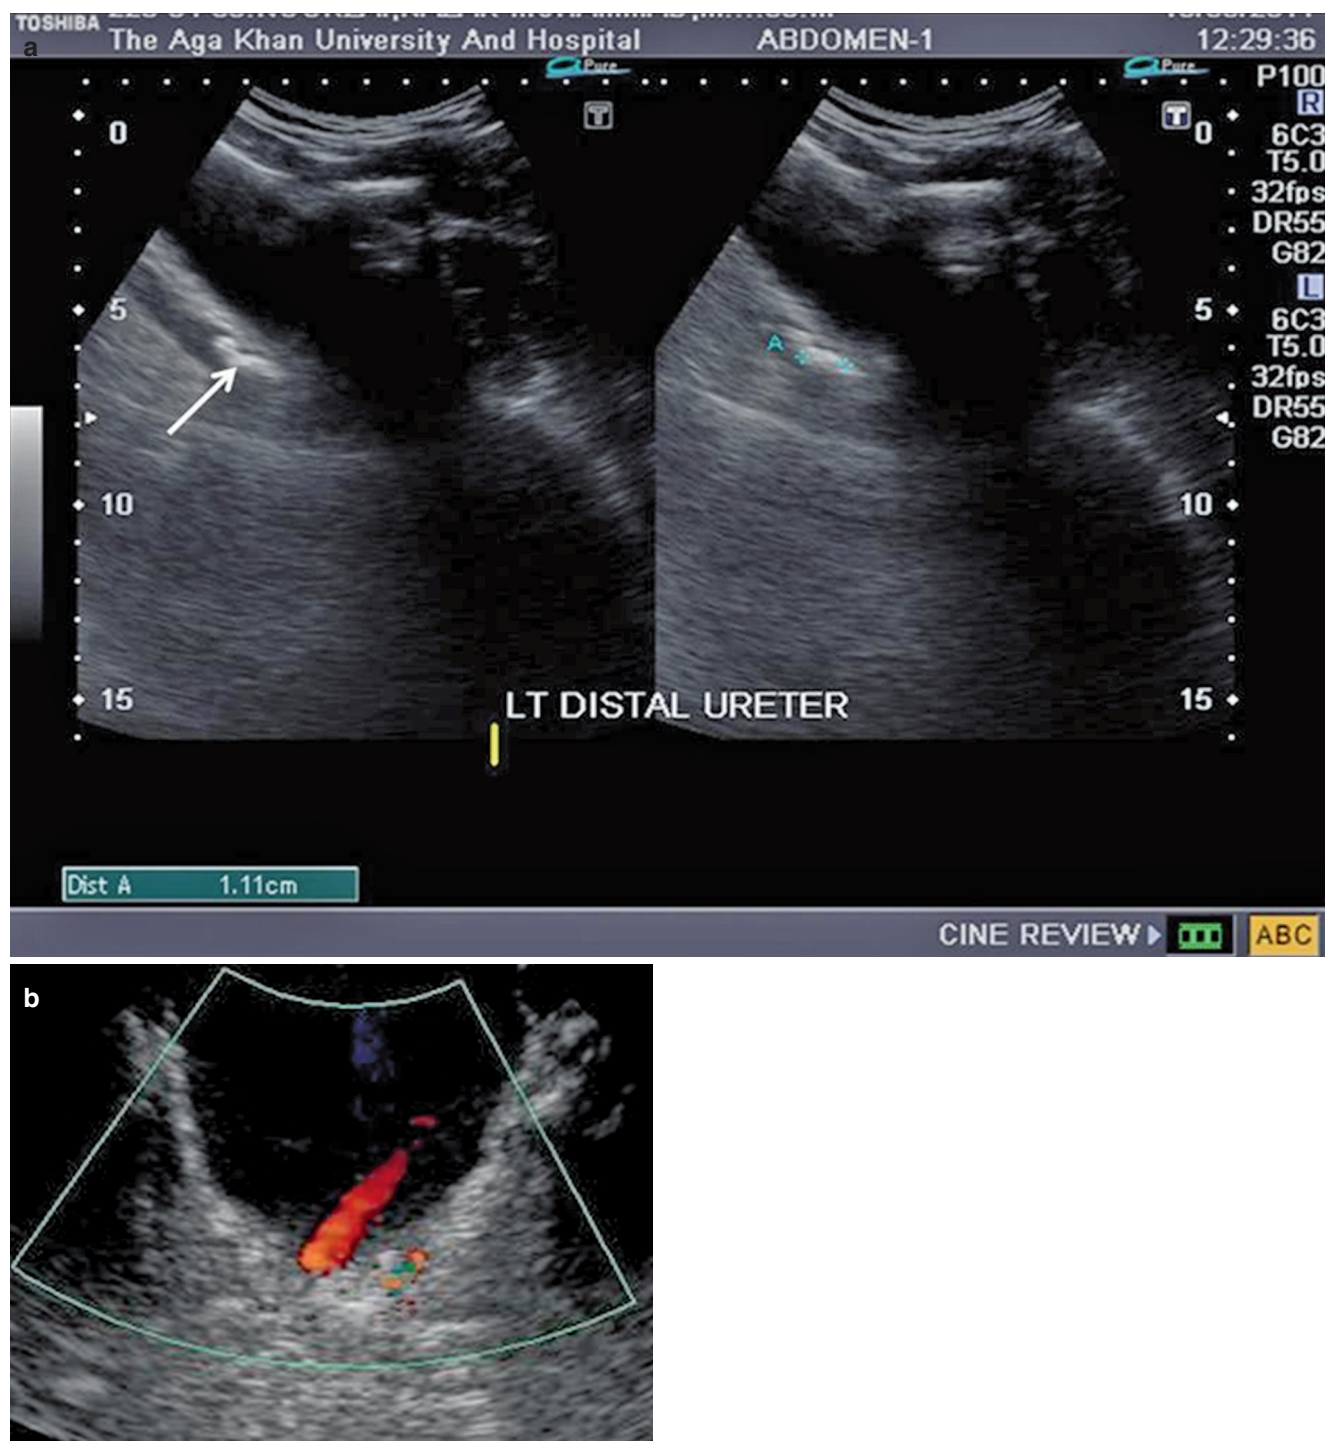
(a, b) Ultrasound showing distal ureteral stone indicated by a hyperechoic head and acoustic shadowing (arrow)
